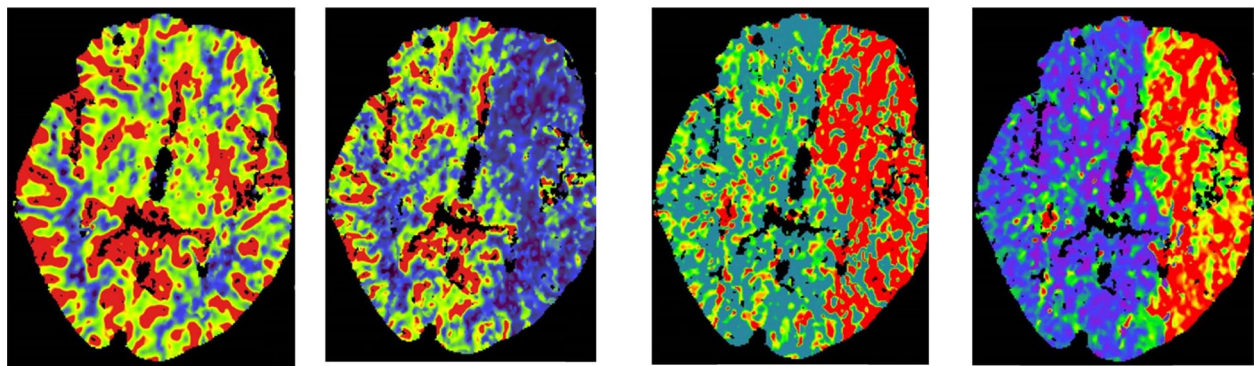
Postoperative computed tomography perfusion imaging showing a large perfusion defect of the entire anterior circulation of the left hemisphere consistent with hypoperfusion due to severe carotid artery stenosis. A Cerebral blood volume. B Cerebral blood flow. C Time to peak. D Mean transit time. Decreased cerebral blood flow with normal cerebral blood volume indicate a small infarct core and large penumbra, e.g. salvageable tissue
